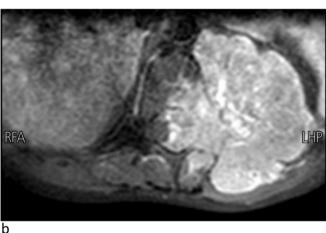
a: T2 sagittal view MRI of dorso-lumbar spine showing a hypointense lesion involving the spinal area of D12-L1 mainly.
